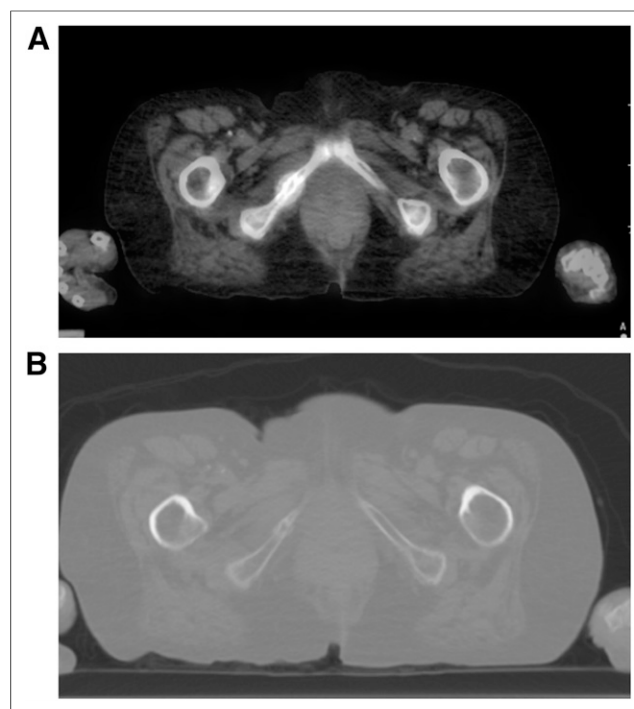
67-y-old woman with bilateral breast cancer underwent ^{18}F -NaF PET/CT for evaluation of osseous metastasis. Focus of intensely increased radiotracer uptake in right ischiopubic junction (A) corresponded to healing fracture identified on low-dose CT (B).
